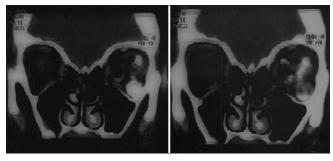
Orbital computed tomography scan, axial incidence, shows an $11 \text{ mm} \times 8 \text{ mm}$ soft tissue mass in lateral aspect of the left orbit
